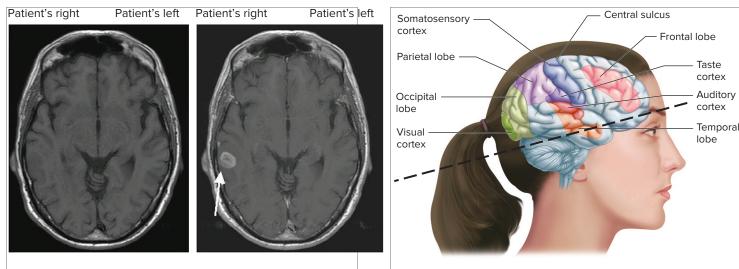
In these images, the settings on the MRI scanner are first set so that the brain tissue looks homogeneously gray, the fat surrounding the brain is lighter, and the water within the cerebral ventricles is dark (left scan). By convention, the MRI images are reversed so that the right side of the brain appears on the left side of the image. The front of the brain is shown at the top of the MRI image. A contrast agent containing the element gadolinium is then infused intravenously into the patient and a repeat scan is taken (right scan). Gadolinium has paramagnetic properties, which are magnetic properties that only arise in the presence of an externally applied magnetic field. When infused intravenously, the contrast agent can enter the brain in regions where the blood—brain barrier (see Figure 6.6) is absent or damaged, as is sometimes the case in sites of brain injury or disease. Once inside the brain, the association of gadolinium with water and fat changes the local environment and causes an area of higher intensity. This MRI scan demonstrates an area of signal abnormality in the right temporal lobe of the brain that measures about 2 cm in diameter (white arrow). The dashed line on the right image shows the plane of the MRI image. Courtesy of Dr. Douglas Woo/Medical College of Wisconsin
